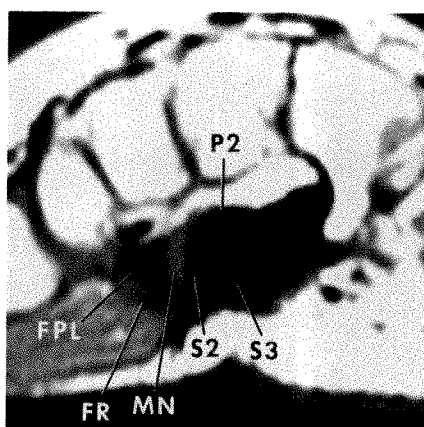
MR image (600/20) shows median nerve interposed between flexor pollicis longus and sublimis 2 and bordered dorsally by profundus 2 when wrist is in neutral position. (See key for abbreviations.)
